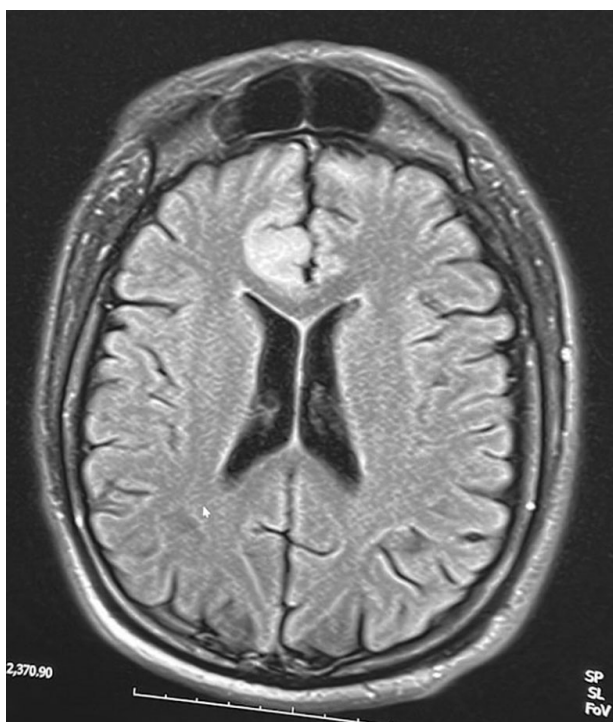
Focal cortical dysplasia in brain MRI
